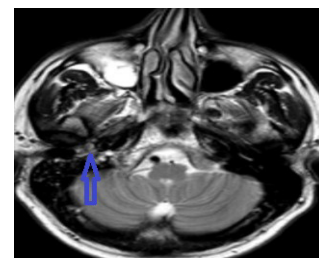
a. Before treatment T2 axial MRI scan (thin blue arrow)
